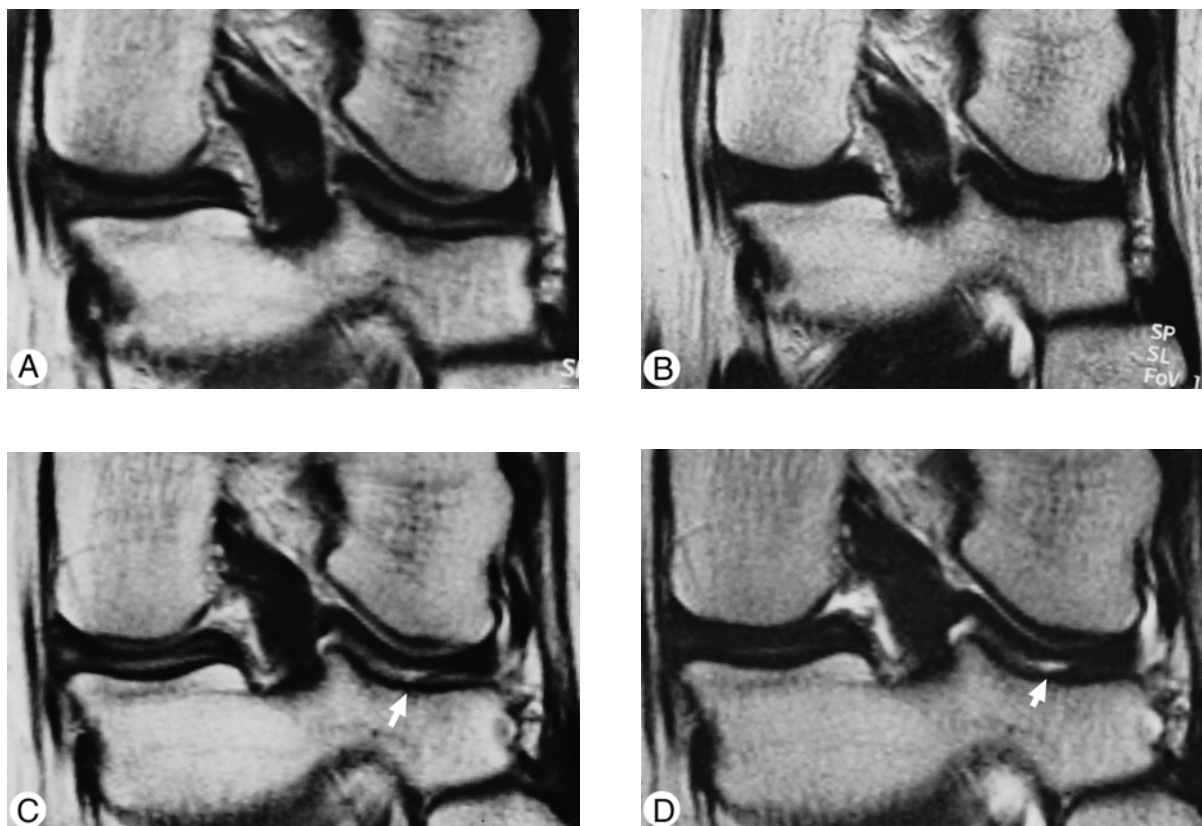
Coronal (A) Pd- and (B) T2-weighted turbo spin-echo MR images show no cartilage defect at the baseline examination in this 57-year-old woman. The corresponding MR images after 25 months, (C) and (D), show that a grade 2 cartilage defect has appeared in the lateral tibial condyle (arrow).
